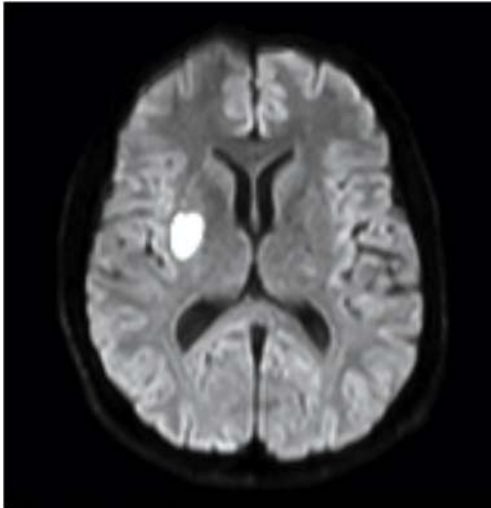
Patient 2. Acute infarct of the left lentiform nucleus detected on DWI.
